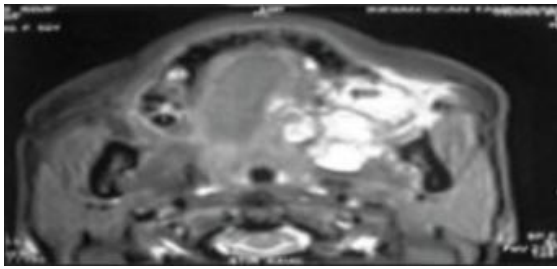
CT scan showing ill-defined heterogeneous expansile soft tissue attenuation lesion.
